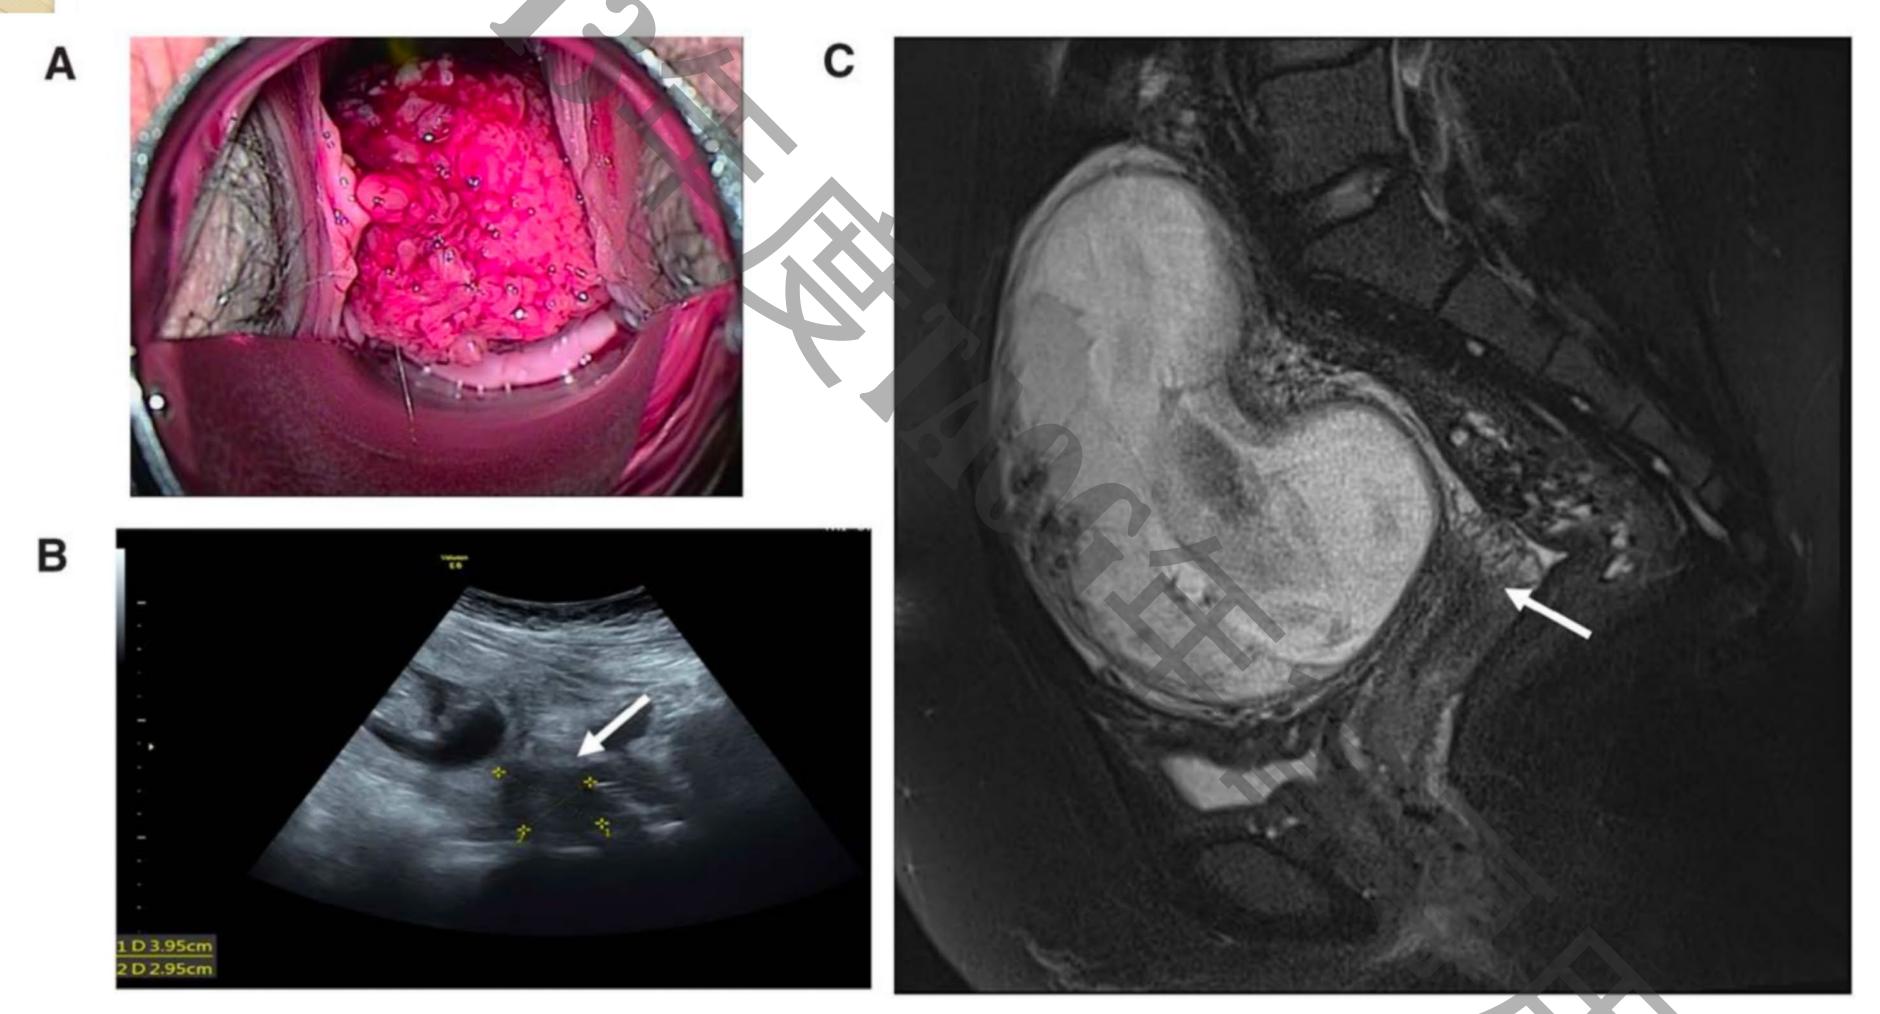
Gross image, ultrasound, and magnetic resonance image (MRI) of the condyloma acuminata. (A) Gross image of the condyloma acuminata. The tumor was 3.5 cm in diameter at the cervical region. (B) Ultrasound of the cervical condyloma acuminata (hypoechoic lesion, arrow). (C) T2 MRI of the cervical condyloma acuminata (arrow). MRI = magnetic resonance image.
